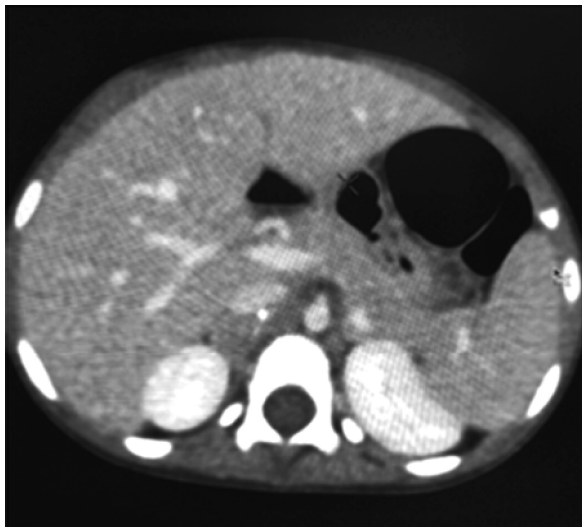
CT abdomen showing adrenal mass with calcification.
